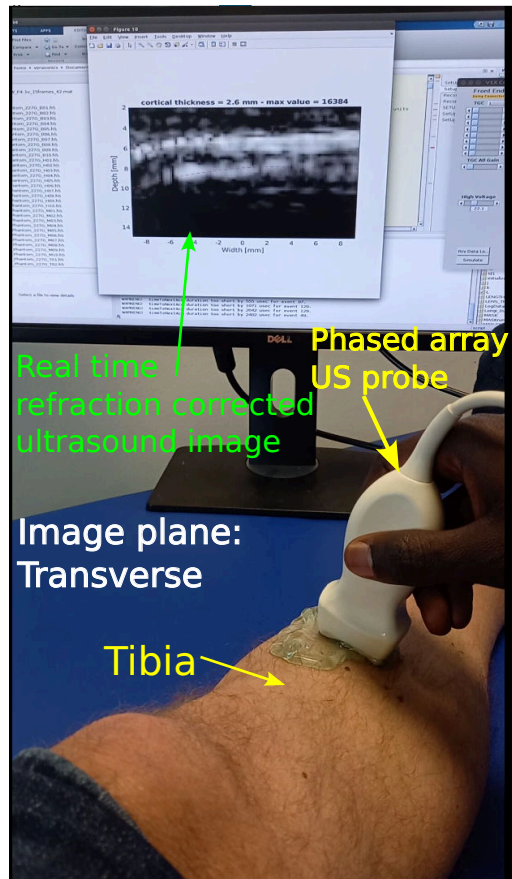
Configuration for acquisition of ultrasound data *in vivo*. Probe is placed perpendicular to bone axis (transverse)
